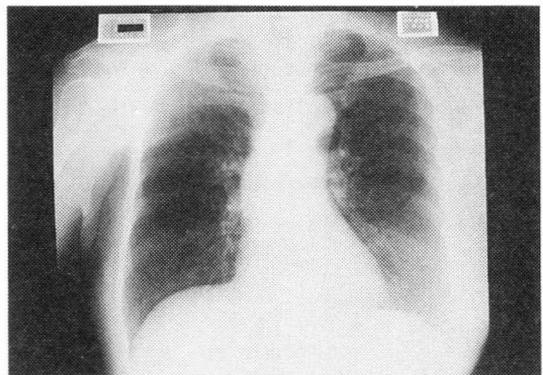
Chest radiograph on admission showing normal findings
